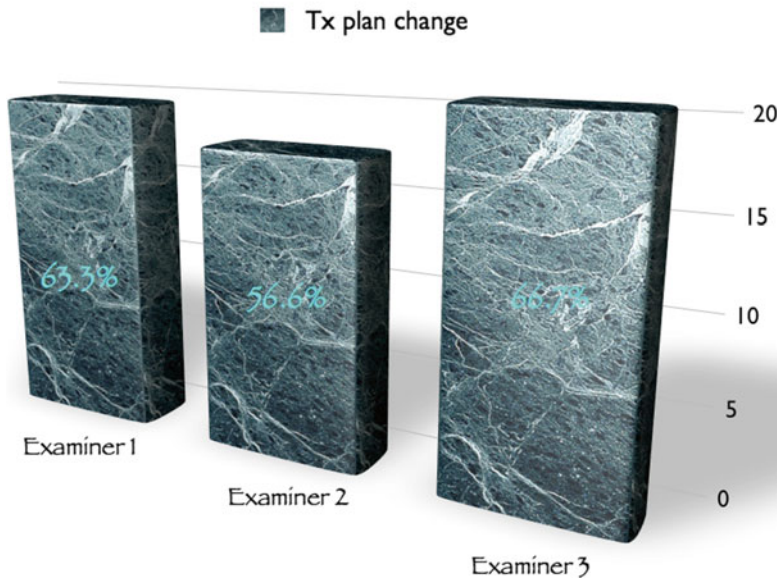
Percentage of treatment plans changed by each of the three examiners after reviewing the CBCT
